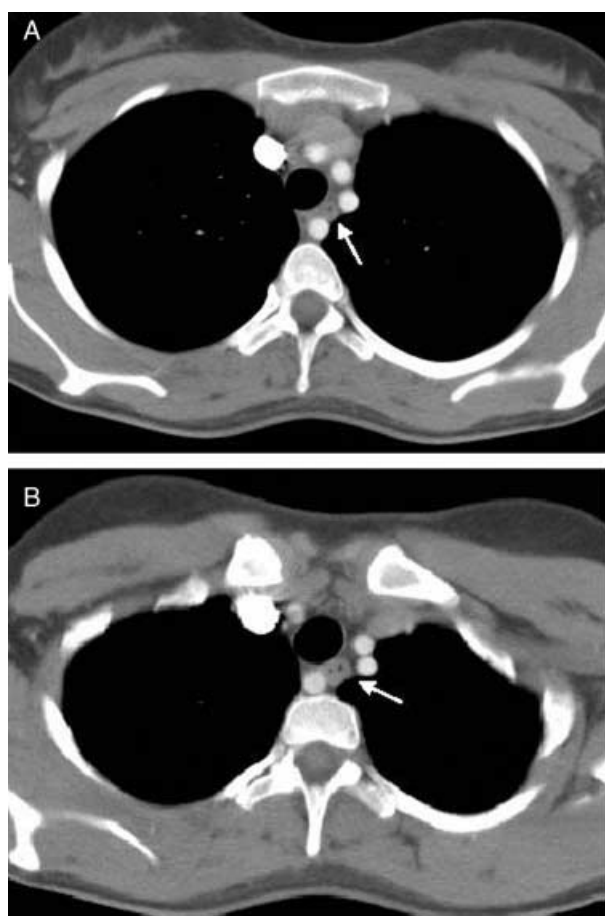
CT scan of the thorax demonstrating: (A) posterior esophageal compression by aberrant vessel; and (B) re-expansion of the esophagus distal to site of compression.
